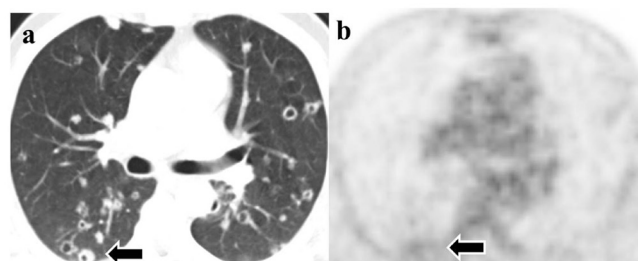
Axial ^{18}F -FDG PET/CT images of a 57-year-old female patient with IMA presenting as multiple cavitary lesions. a) CT image (lung window) showing multiple bilateral small cavitary nodules (arrow). b) PET image demonstrating mild ^{18}F -FDG uptake in the nodules (arrow)
